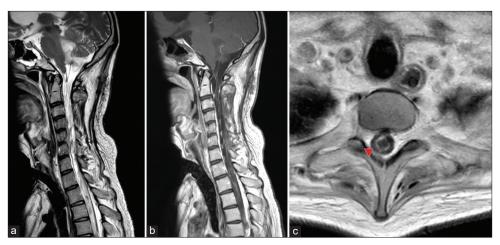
Cervical gadolinium contrast-enhanced magnetic resonance (MR) imaging. (a) T2-weighted sagittal image showing severe atrophy of the spinal cord with little or no normal spinal cord tissue present. A liquid mass was observed in the fourth ventricle, suggesting a tumor with liquefaction changes. (b) Gadolinium-contrasted T1-weighted sagittal image. Partial contrast enhancement diffusely presented in the spinal cord, with spinal cord dissemination or residual tumor suspected. (c) Syringomyelia was observed on the axial T1-weighted plain MR image (red arrowhead).
